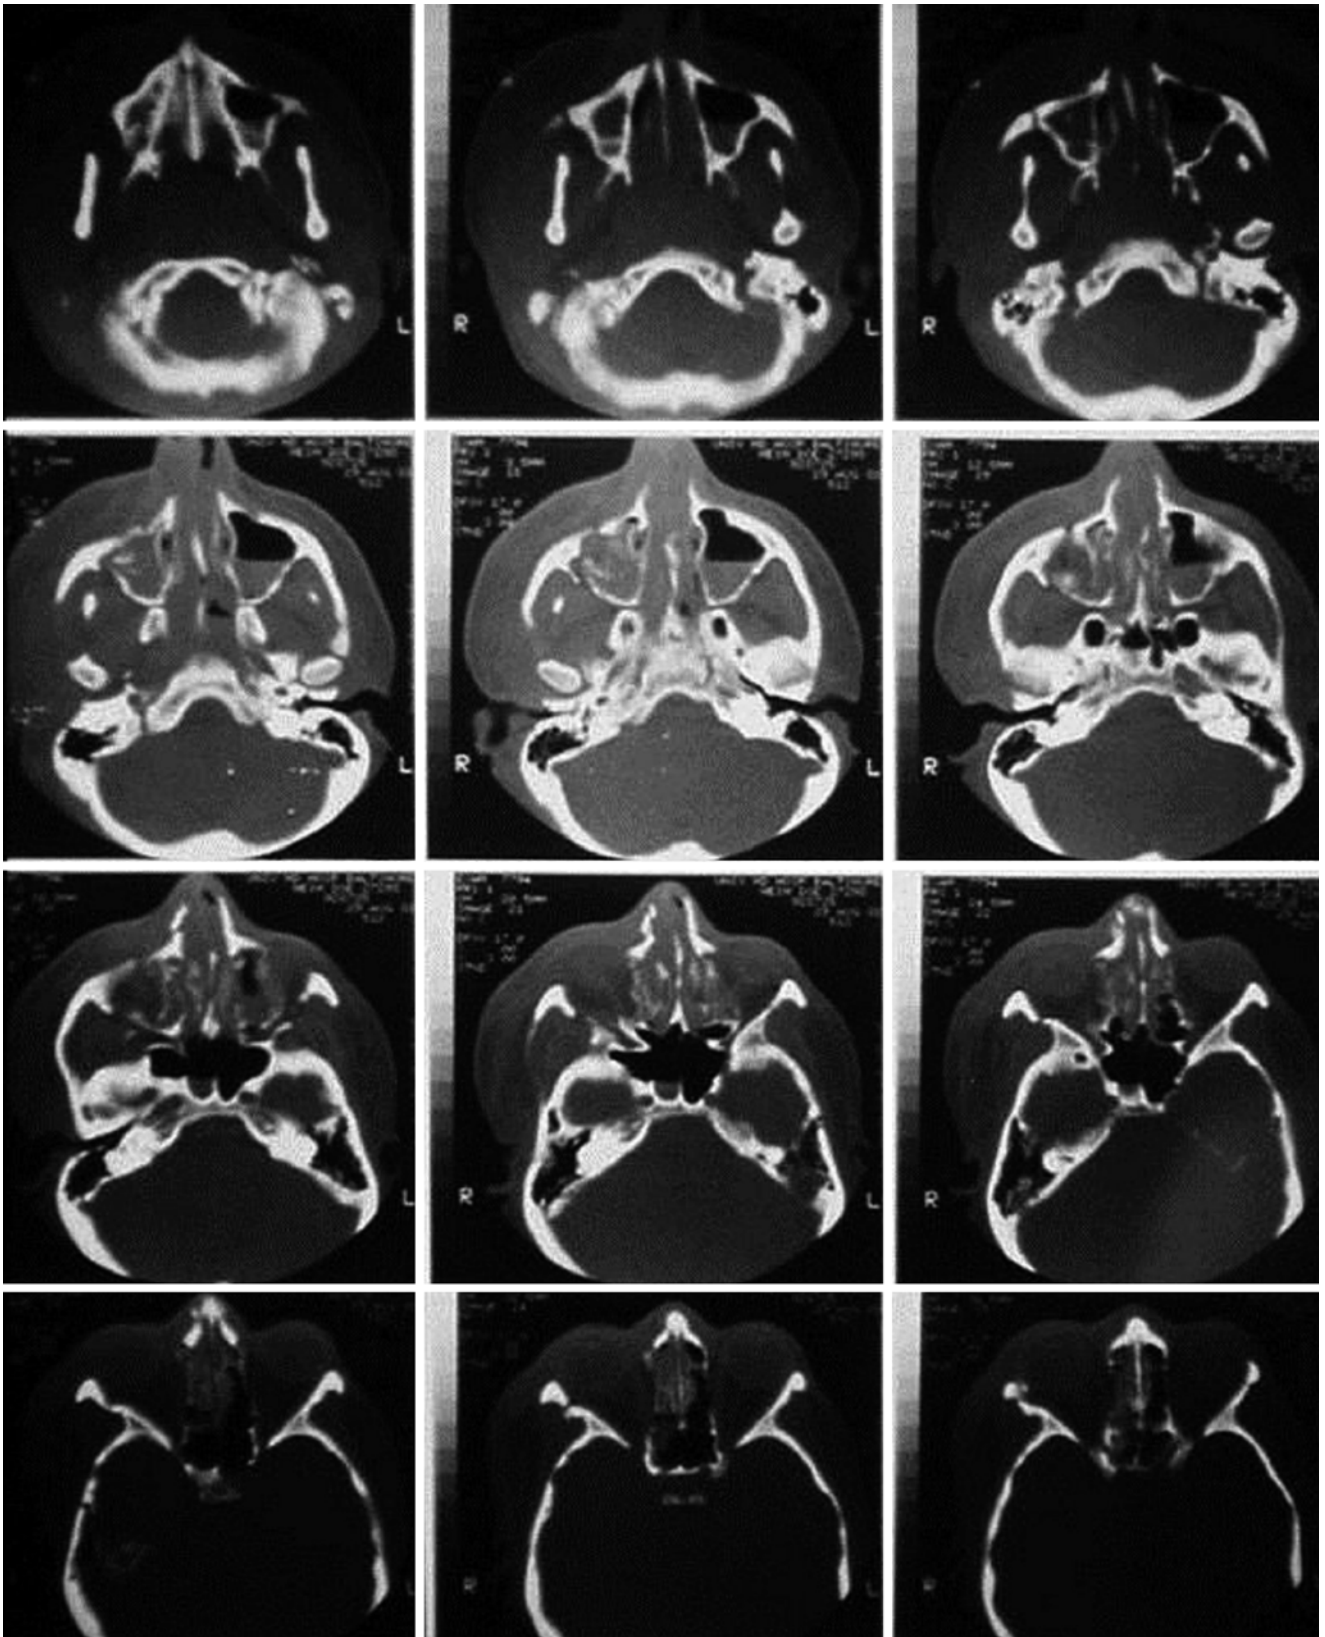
Axial CT scan of a zygoma fracture
